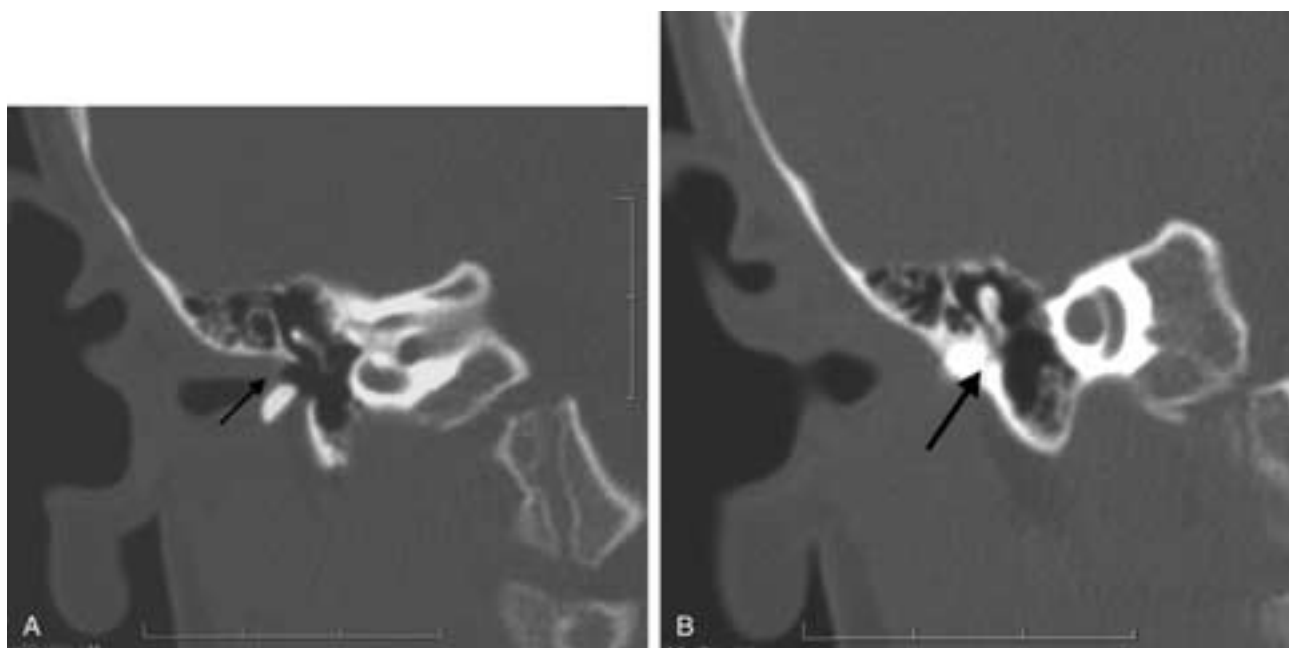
EAC stenosis. A, Coronal CT image at the level of the incudostapedial joint and oval window showing stenosis of the EAC with membranous apposition of the superior and inferior walls (black arrow). B, Coronal CT image of the same patient more anteriorly showing a bony atretic plate (black arrow) with fusion of the handle of the malleus to the plate.
